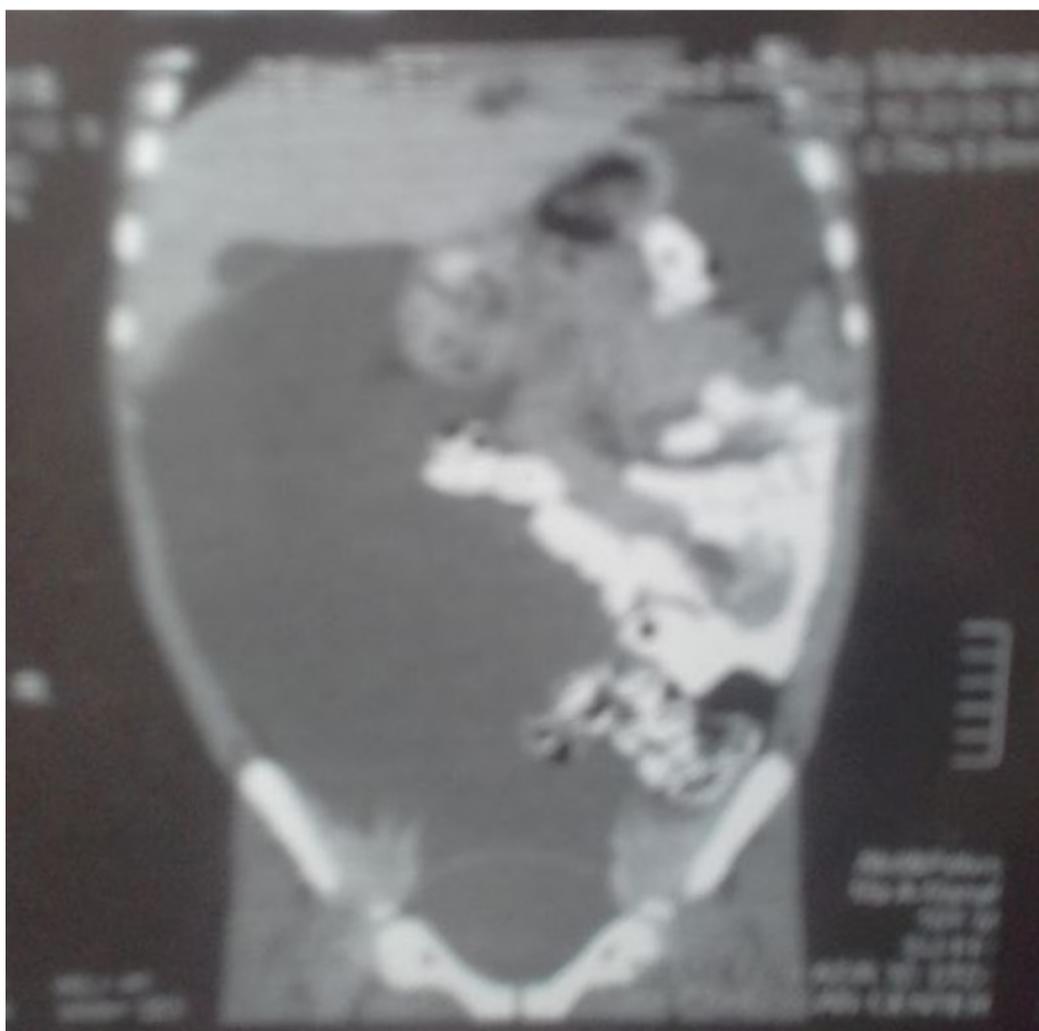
CT scan shows the mesenteric cyst
